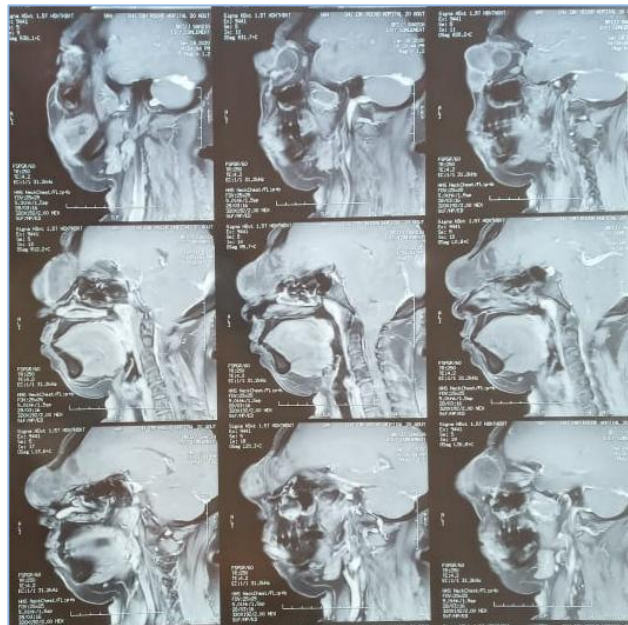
MRI showing the naso-orbital encephalocele
